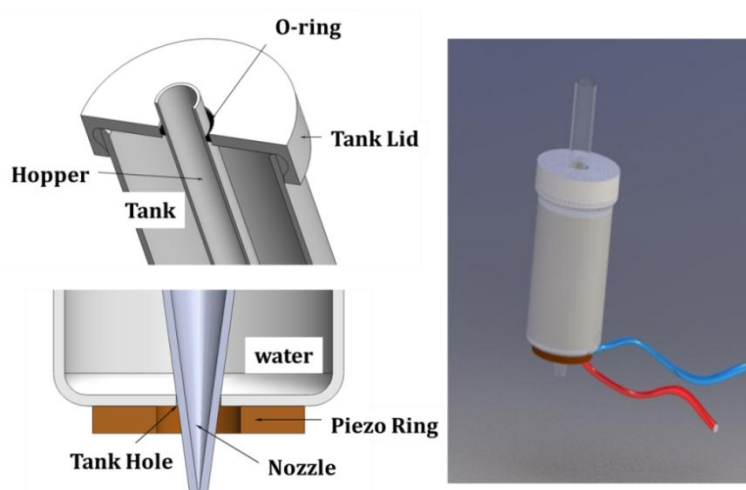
6 Sketch of ultrasonic vibration dispensing device
